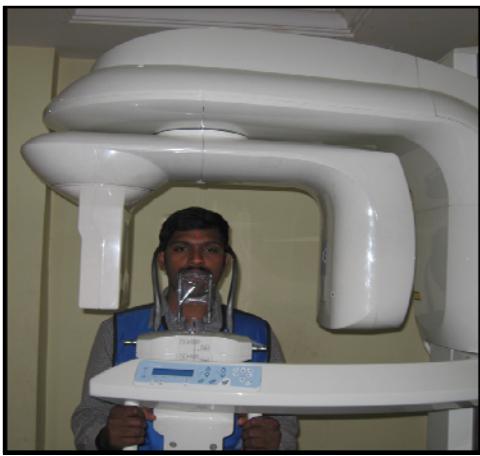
Cone Beam Computed Tomography Machine
